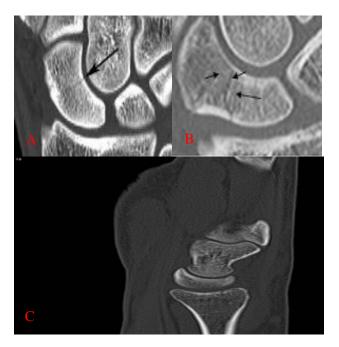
A, B, C- fracture scaphoid in CT scan of the same patient on day 1 injury.
